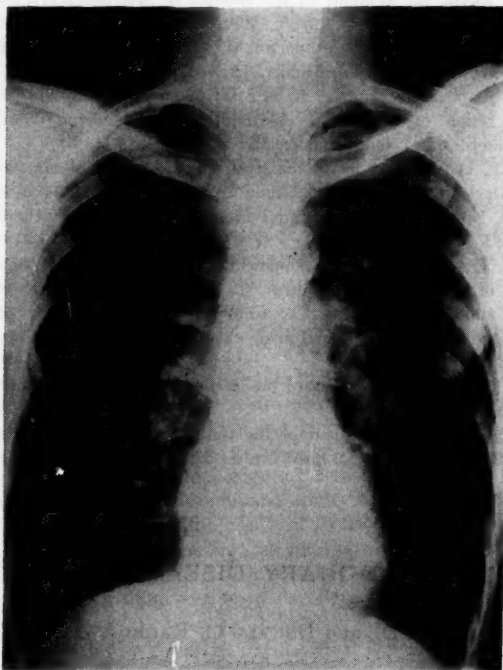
X-ray of chest of patient, 9/11/57.
